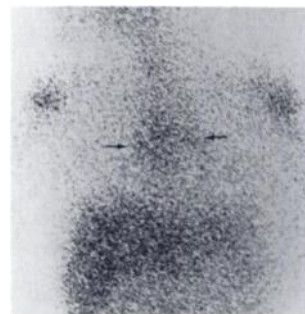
From 9-yr-old female with acute lymphocytic leukemia and normal chest radiograph. Note thymic uptake of Ga-67 on 48-hr postinjection image (arrows). Biopsy showed thymic hyperplasia.
